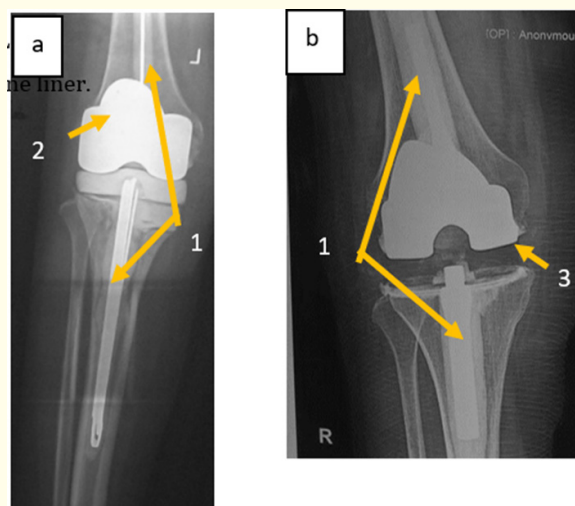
X-rays of knee joints with cement liner (a) and poly liner (b) spacers.
